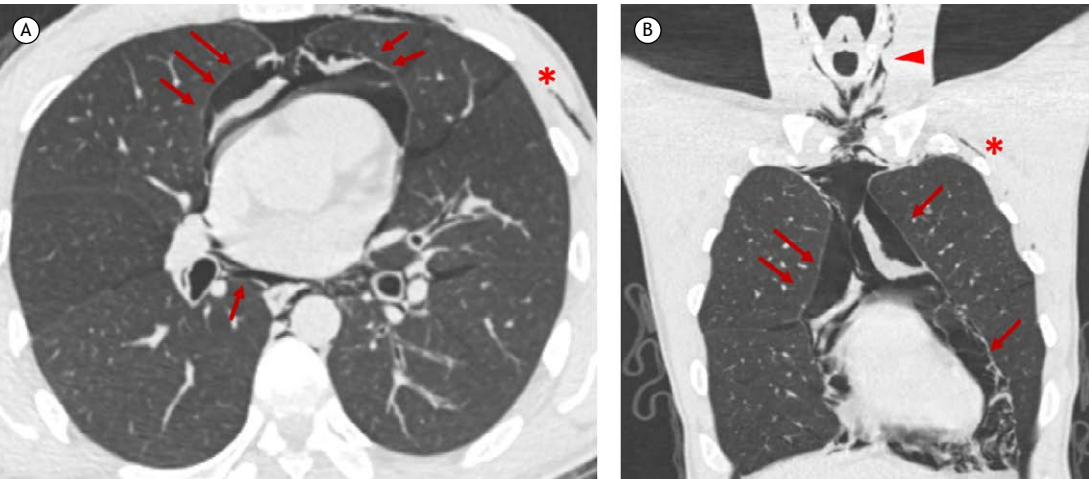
Axial (A) and coronal (B) CT scans with lung window settings showing the presence of air in the mediastinal compartment, with dissection of gas along the pericardium and pleura (arrows), in addition to the presence of air in the posterior mediastinum, with dissection of gas to the neck spaces (arrowhead). Note also the presence of subcutaneous emphysema (asterisk).
